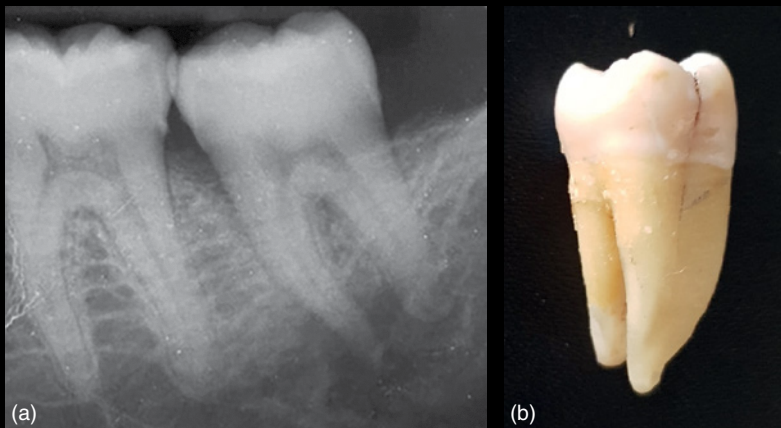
Periapical radiograph and photograph of the LL7 with intact clinical crown. Note the mesial vertical bone loss with apical radiolucency and the corresponding crack with radicular extension on the mesial root.
